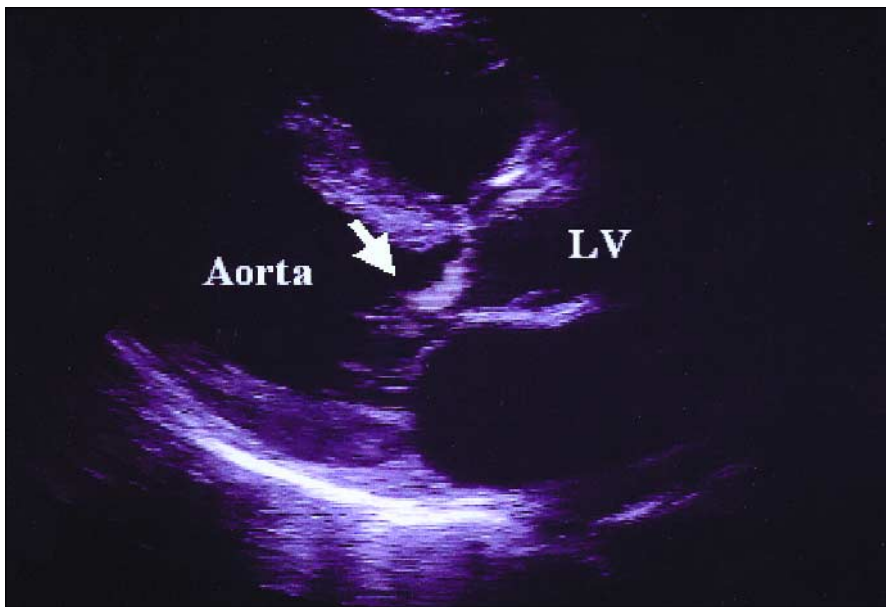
Two-dimensional echocardiogram shows a long axis view of the heart. The aorta and left ventricle (LV) are indicated. There is a 1 x 0.5 cm vegetation attached to the left coronary cusp of the aortic valve (arrow). During diastole the vegetation could be seen prolapsing from the aortic root into the left ventricular cavity.
